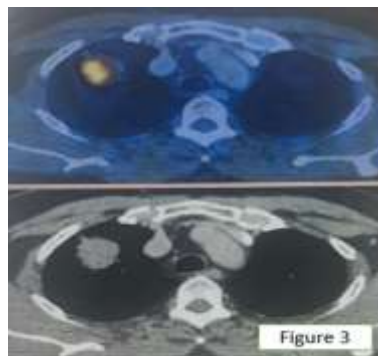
PET CT showing right upper lobe mass
